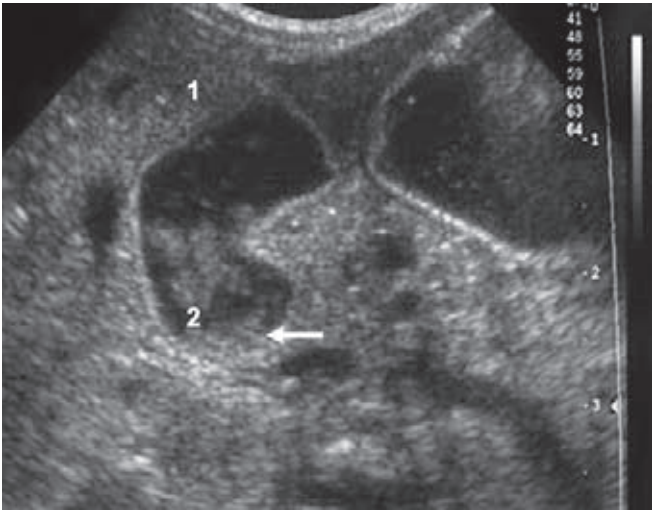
Upper abdominal ultrasound in a neonate showing dilated and fluid filled first (1) and second (2) parts of the duodenum due to a web (arrow)
